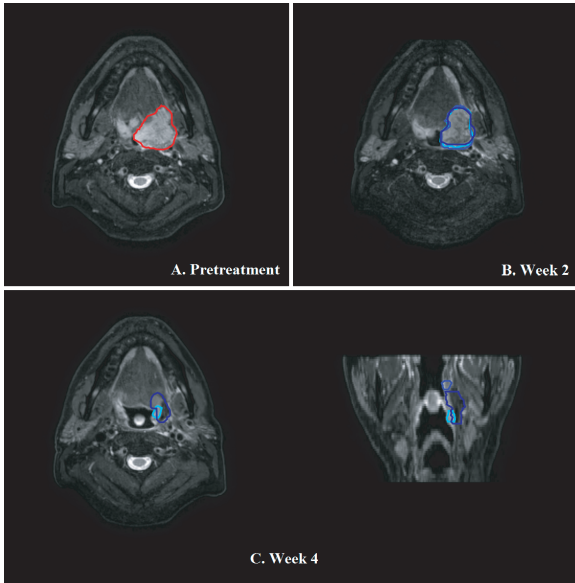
T2 weighted MR images of the patient with the lowest interobserver agreement at week 4 (patient 16). A: MRI prior to the start of treatment with delineation of clinical GTV in red. B: MR images obtained in week 2 of treatment, the three observers are represented by different shades of blue. C: Transverse and coronal images obtained in week 4 of treatment.
